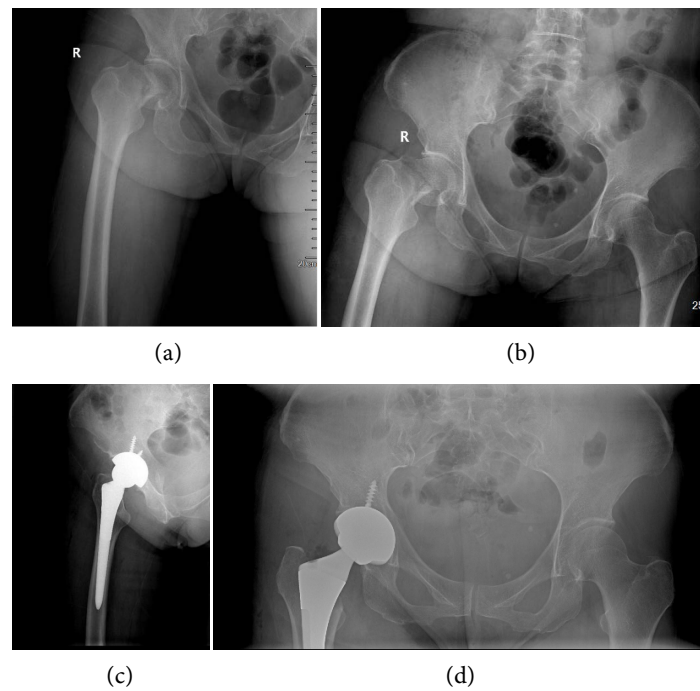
Female, 58 years old, Right femoral neck fracture, THA through the PLA. (a) (b) Preoperative pelvis AP and Lateral radiograph of hip joint shows fracture of left femoral neck; (c) (d) Postoperative pelvis AP and Lateral radiograph of hip joint shows that the prosthesis is in good position.
